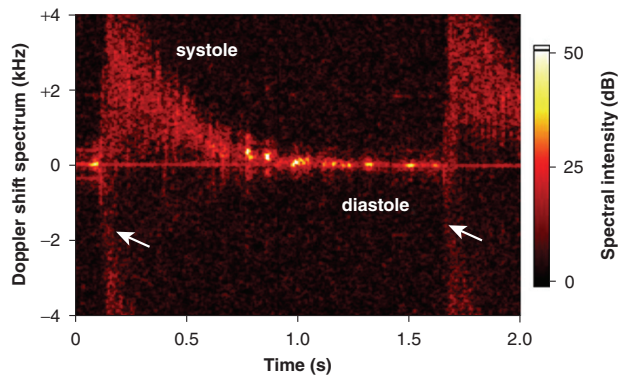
Doppler spectral display of the D-OCT system. The full Doppler spectrum represents the velocity distribution of the blood flowing within the analysis window, which is the gap in the yellow line shown in Figure 32.6(b). Notice the rapid onset of systole and the aliasing caused by the peak velocity (arrows), as well as the relatively longer time for diastole (heart relaxation)¹⁰
